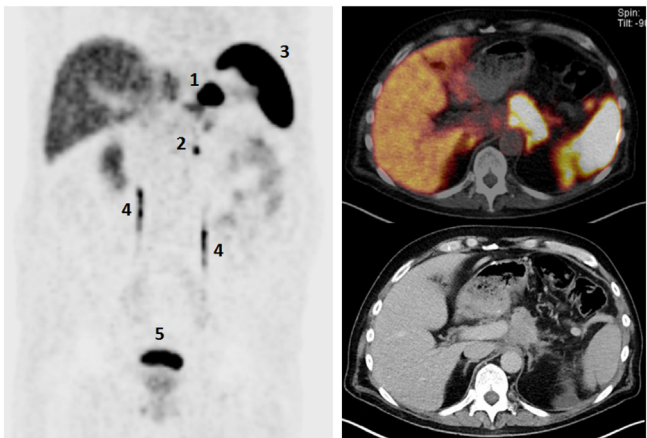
Neuroendocrine tumor of the stomach (Ga-68)-DOTANOC PET-CT, pT4a, pN0 (0/14), pL1, pV1, G2 (Ki67: 12%): 1, primary tumor, 2, lymph node metastases; 3, spleen, 4, ureters, 5, urinary bladder. *Courtesy: Prof. R. Braren, Klinikum rechts der Isar.*
